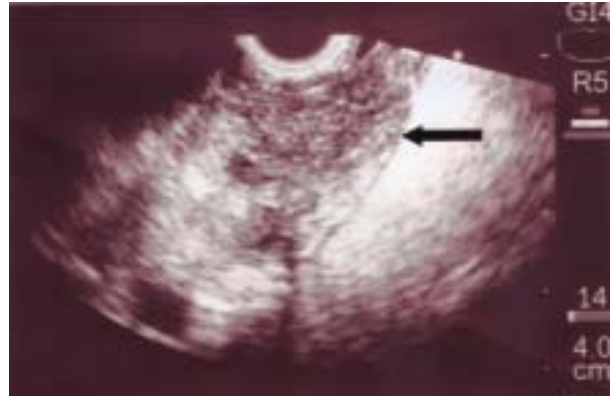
Endoscopic ultrasound image showing the submucosal growth (arrow).
